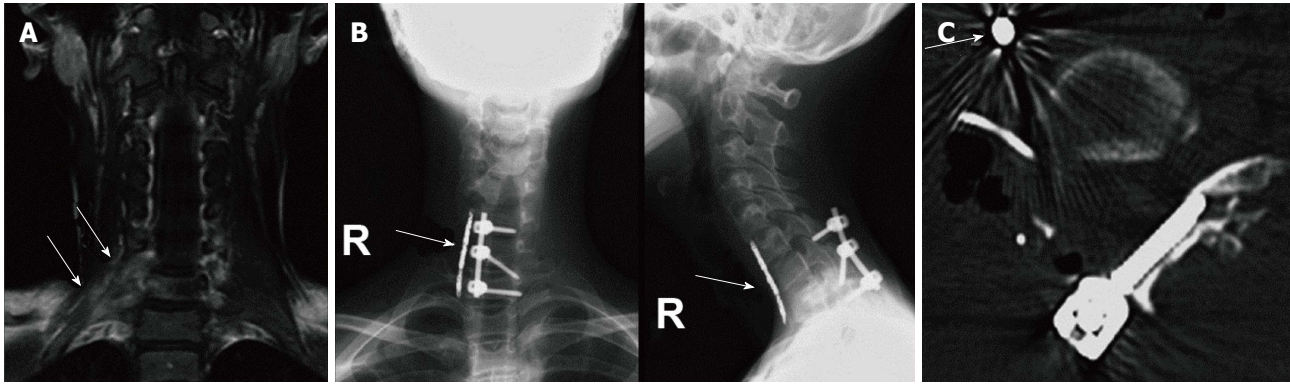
Case 2. A: A magnetic resonance imaging scan image showing a Ewing's sarcoma involving the right C7 and C8 nerve roots (arrows); B: Roentgenograms showing the laminar screws, which are placed at the C6–Th1 levels with a preoperative embolic coil in the right vertebral artery (arrows); C: A computed tomography image showing a C6 laminar screw penetrating the facet joint and a preoperative embolic coil (arrows).
